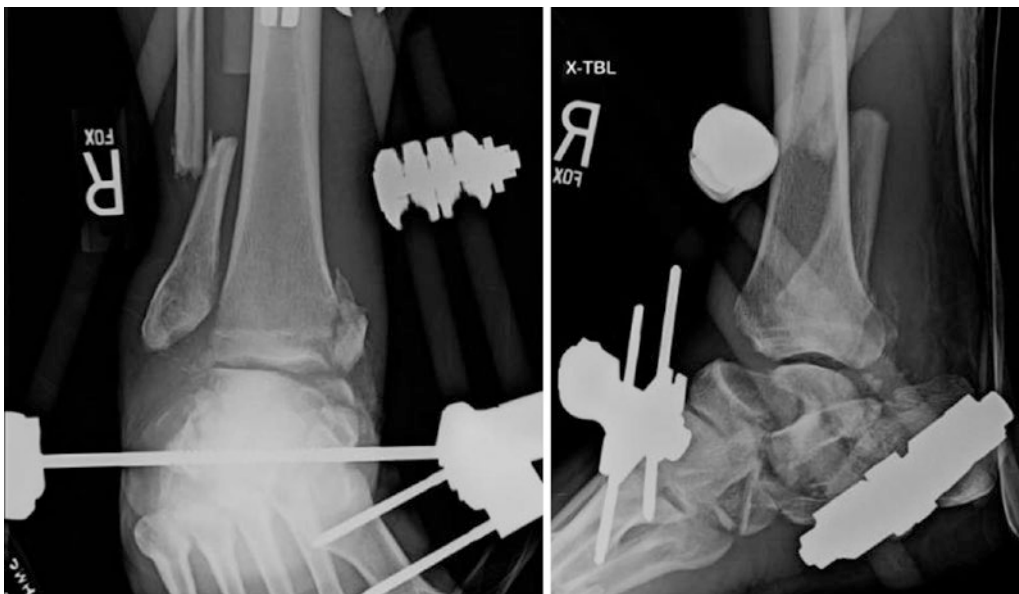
AP and lateral radiographs of a patient status post-external fixation, transferred for the management of a complex ankle and hindfoot injury with near total talar bone loss. Note the shortening through the ankle joint
